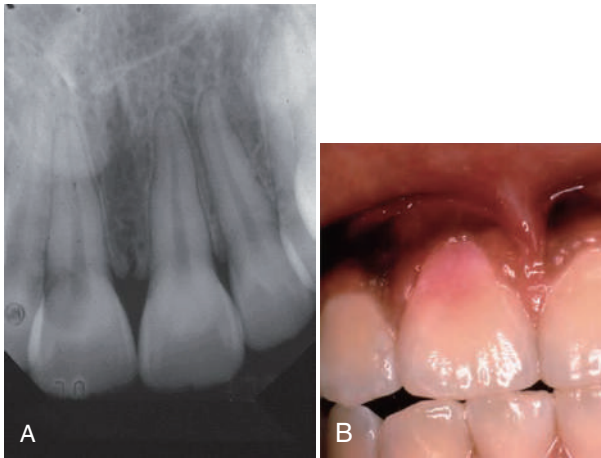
Pink spot of subepithelial external inflammatory root resorption. A, Radiographic appearance. B, Clinical appearance.
